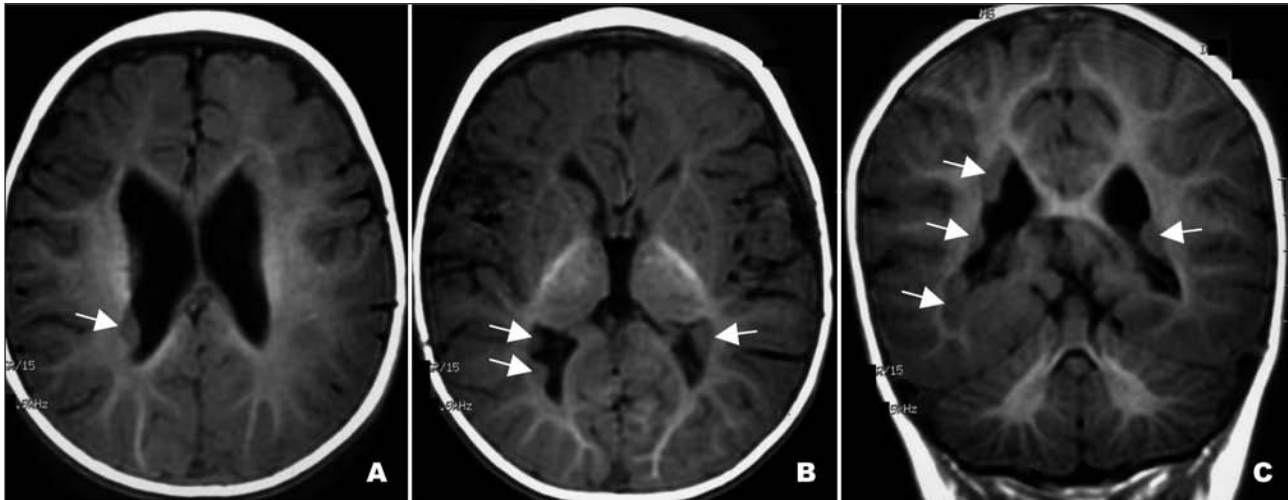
MRI showing multiple foci of periventricular nodular heterotopia at left frontal and bilateral parieto-occipital regions, on T1-weighted axial (A,B) and coronal (C) cuts.
